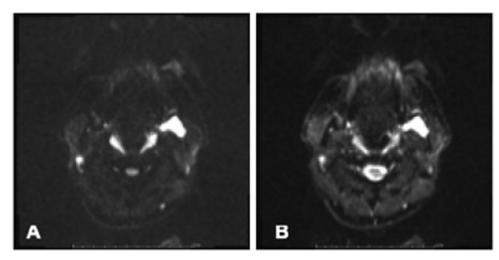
Diffusion-weighted imaging (DWI) using 2 distinct b values (A) b = 0; (B) b = 800. The lesion was an odontogenic keratocyst in the left posterior mandibular region of a 22-year-old male. The lesion exhibits a hyperintense pattern (axial slices).
